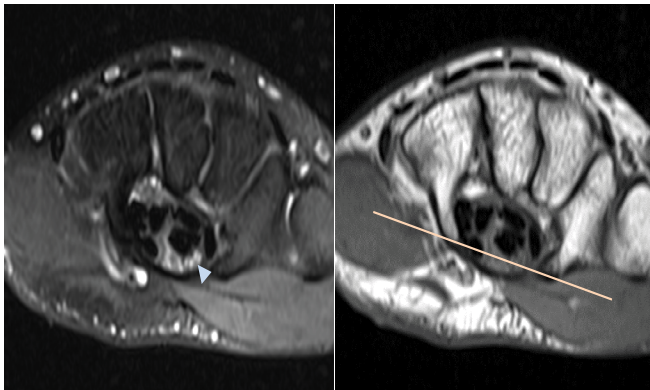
Axial T2-weighted fat-suppressed MR image demonstrates mild reactive signal alteration of the adjacent bifid median nerve, compatible with reactive neuritis. Axial T1-weighted image demonstrates mild volar bowing of the flexor retinaculum secondary to mass effect from the thrombosed artery.
